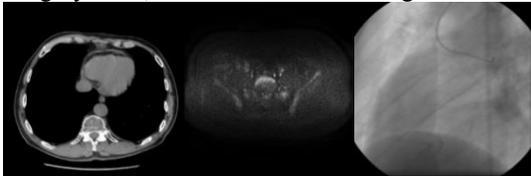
Set of greyscale DICOM images used in our experiments. Left to right, top to bottom: CT scan 512\*512 8-b pixels; MRI 256\*256 8-b pixels; X-ray angiography 512\*512 8-b pixels
